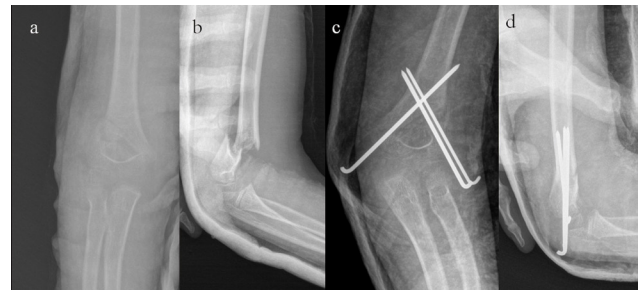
a,b) Anterior-posterior (AP) and lateral x-rays of a 9 year old male sustained a Gartland type 3 SFH after a fall from a tree. c,d) Early postoperative AP and lateral x-rays after closed reduction and CP showing anatomic reduction and stable fixation of the fracture. Patient had an ulnar nerve palsy at postoperative first examination. Medial pin was not removed not to disrupt the stability of the fixation. Note also the over-introduced lateral pins
